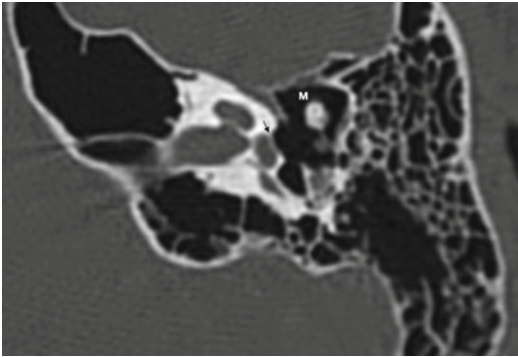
Computed tomography of a left ear with aplasia of stapes suprastructure and the long process of the incus. *M* malleus; stapes footplate (*arrow*)
